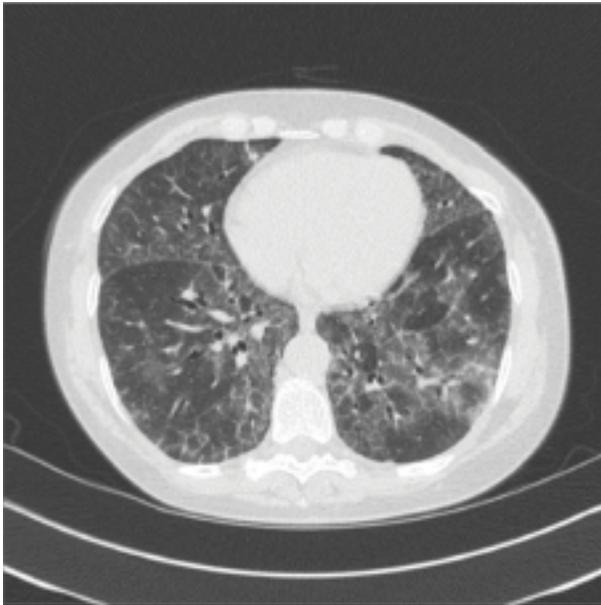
Chest CT scan reveals bilateral ground-glass and reticular opacities in the lingula and lung bases. Interlobular septal thickening is present predominantly in the lower lung fields.
